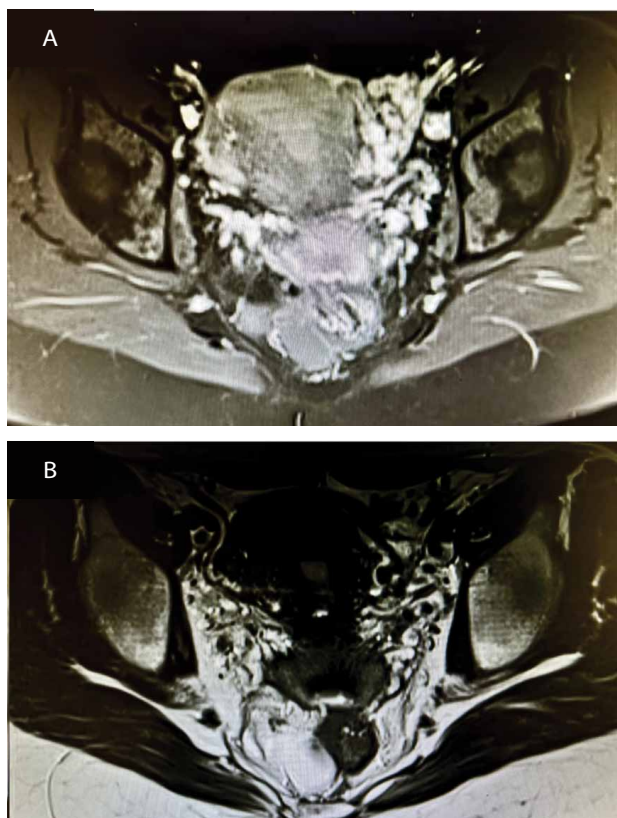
A: T1-weighted MRI sequence indicating rectal protrusion below S5 level. B: T2-weighted MRI sequence indicating rectal protrusion below S5 level.
